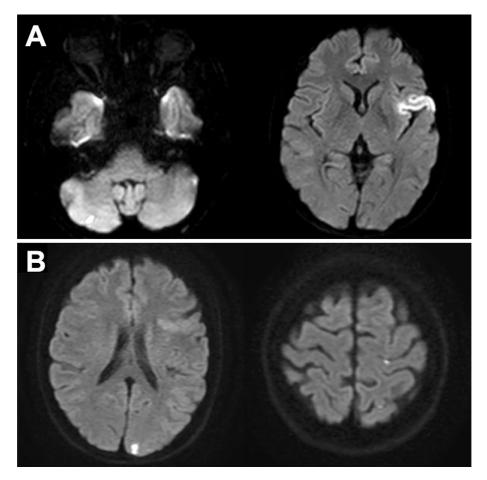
A: Diffusion-weighted magnetic resonance imaging (DWI) revealed multiple infarctions on admission at the initial onset. B: DWI revealed recurrent cerebral infarctions.
